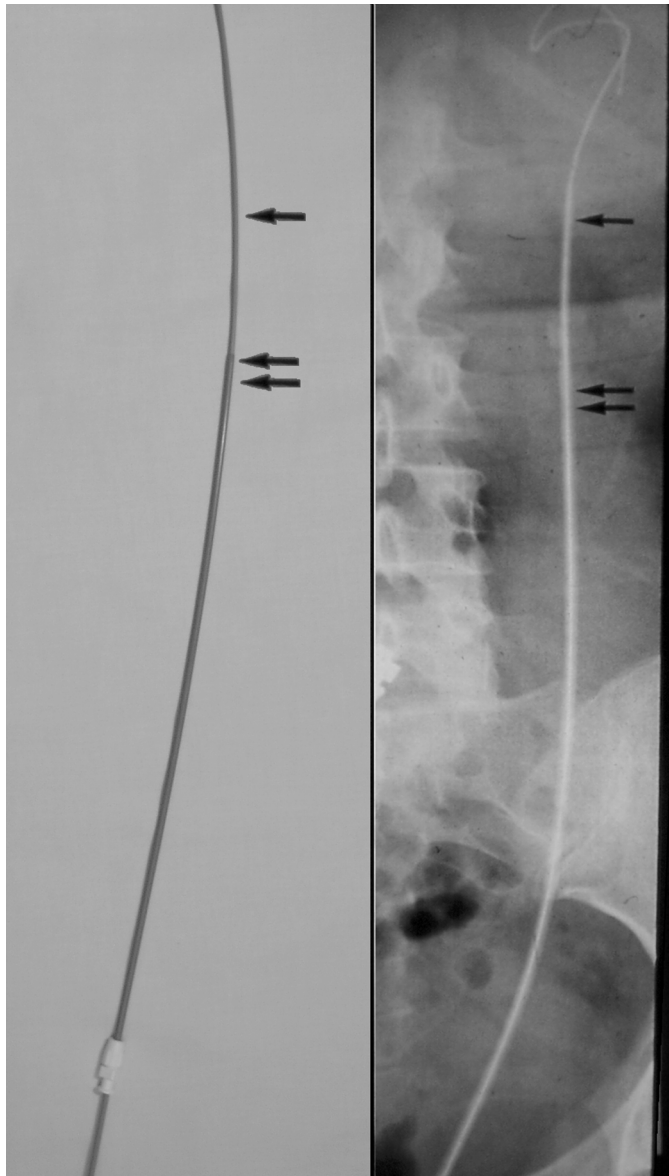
Table-top and corresponding radiograph of the 8/10 coaxial dilator set. After advancement of the guidewire into the renal pelvis, the cystoscope is removed and the remainder of the procedure is performed under fluoroscopy. The 8/10 dilator set is advanced over the guidewire. The double arrows correspond to the end of the 10-Fr sheath. The single arrow delineates the end of the 8-Fr dilator which is almost in the renal pelvis. The 10-Fr sheath is advanced up to the hub of the patient's urethral meatus and the proximal end reaches the midureter in this case since the patient is female. In males, the 10-Fr sheath reaches just above the iliac vessels.
